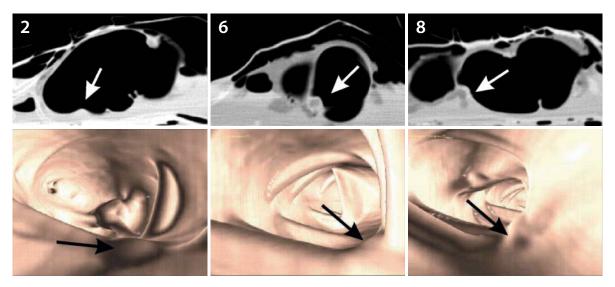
Three representative polyps shown on axial CT scans (upper row) and the same polyps presented on virtual endoscopic views (lower row)
